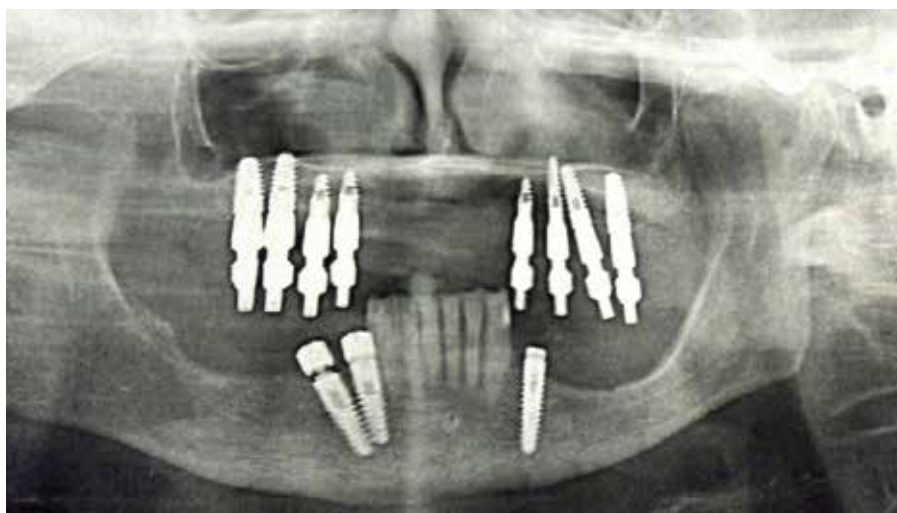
A panoramic x-ray revealed implants in 27, 26, 25, 24, 14, 15, 16, 17, 34, 45 and 46. The patient presented scant separation to the inferior alveolar nerve in the third quadrant due to inferior maxillary atrophy caused by the absence of teeth.
